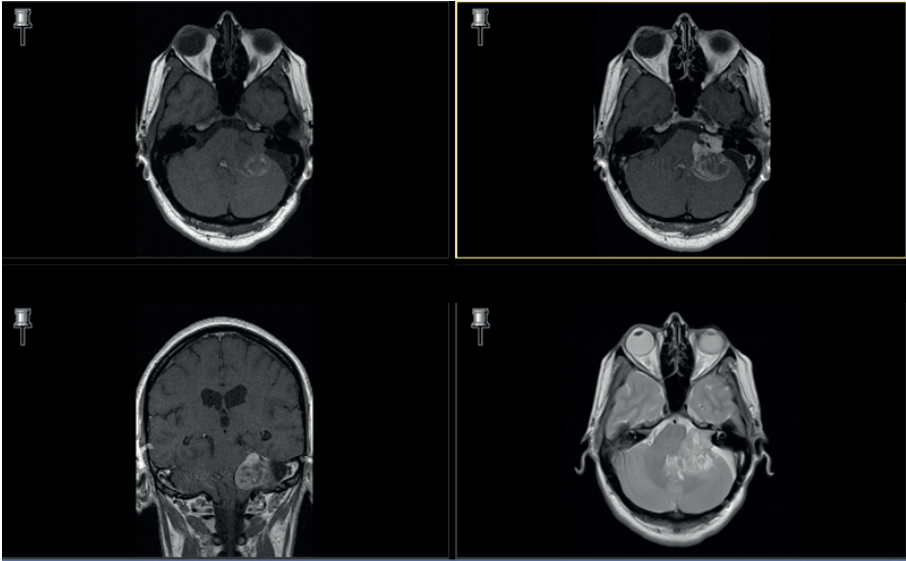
MRI head T1 pre and post contrast and T2 image showing residual left acoustic neuroma with hematoma.
